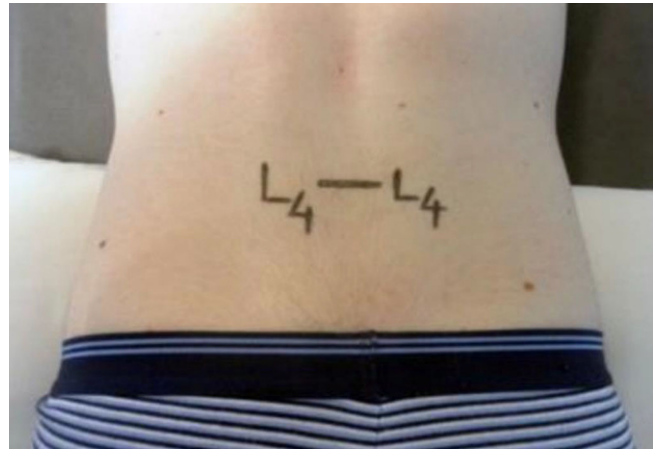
▲ Reference marks for probe location during ultrasound evaluation of the LMul muscles
